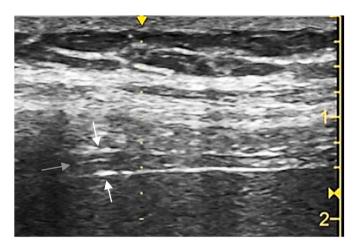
B-mode ultrasound image of the diaphragm at the opposition zone. Borders of the diaphragm are indicated by white arrows. The central fibrous layer is indicated by the horizontal gray arrow.
